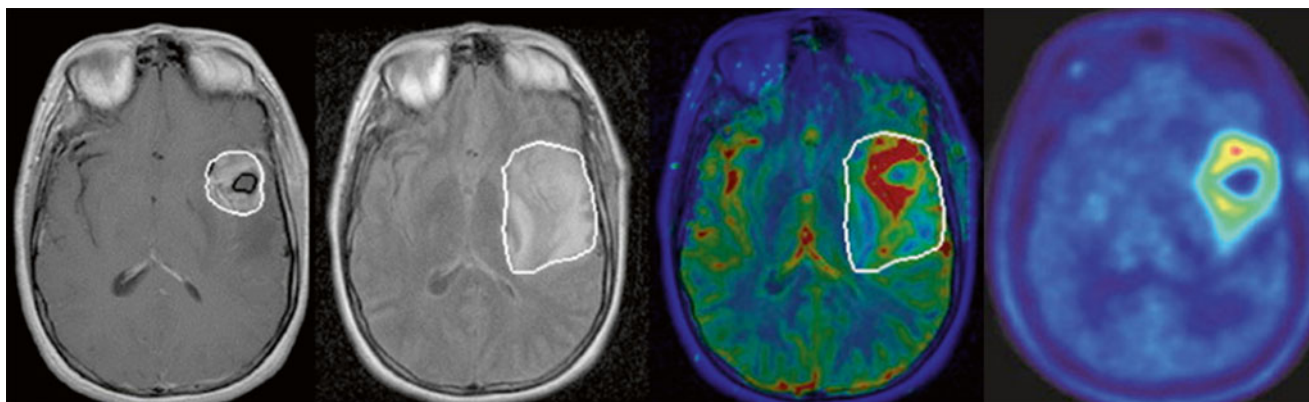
Multimodality MR imaging for target volume definition for a left temporal glioblastoma. T1 post-gadolinium notes a contrast-enhancing lesion (*far left image*) with significant peritumoral edema shown on MR FLAIR imaging (*second image from left*). Perfusion map shows areas of high CBV (*red*) extending beyond the contrast-enhancing tumor rim as
